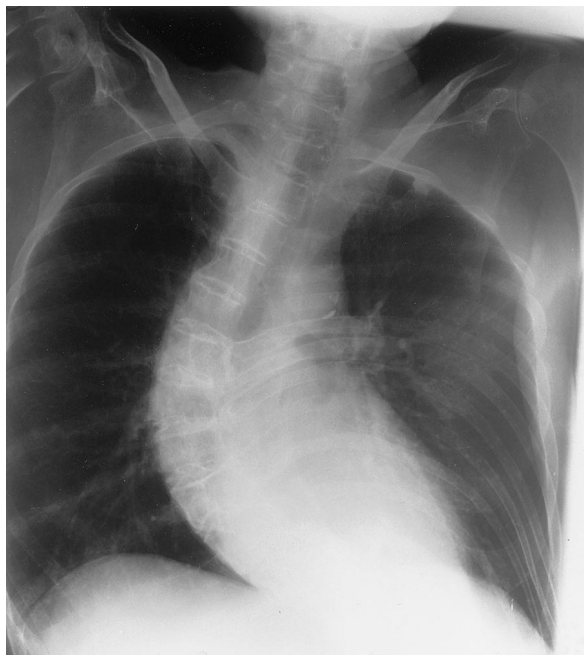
Chest radiograph showing severe thoracolumbar scoliosis with normal lung parenchyma.
